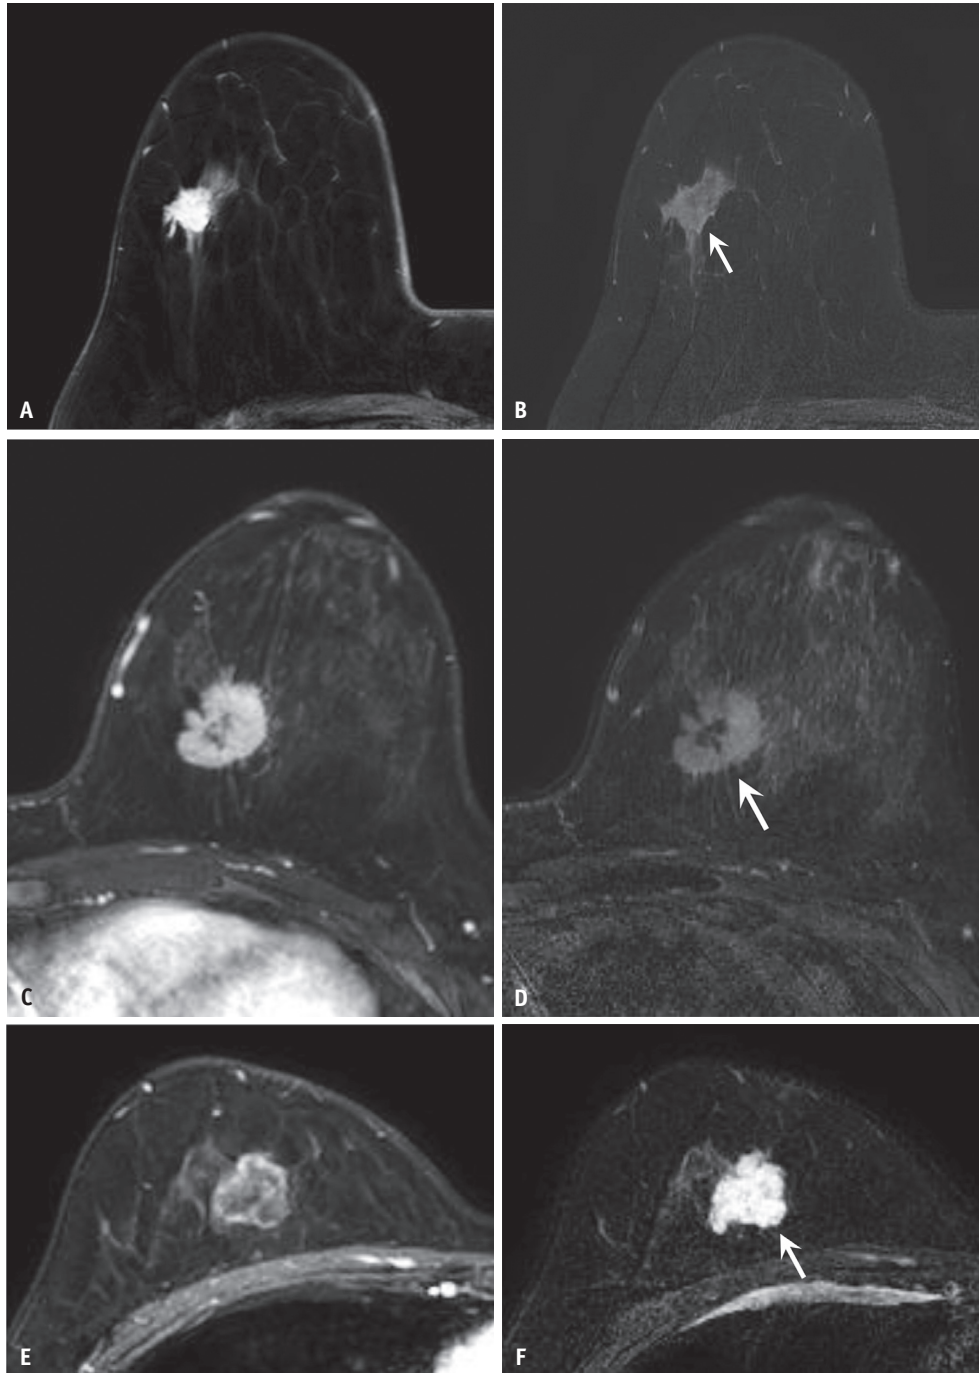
Examples of intratumoral T2 signal intensity grades. A, B: Fat-suppressed T1-weighted early contrast-enhanced (A) and T2-weighted axial breast MR (B) images show intratumoral T2 signal intensity (arrow) lower than or equal to that of the surrounding breast tissue (grade 0). C, D: Fat-suppressed T1-weighted early contrast-enhanced (C) and T2-weighted axial breast MR (D) images show moderately high intratumoral T2 signal intensity (arrow), which remains lower than that of water (grade 1). E, F: Fat-suppressed T1-weighted early contrast-enhanced (E) and T2-weighted axial breast MR (F) images show intratumoral T2 signal intensity (arrow) as high as that of water (grade 2).
